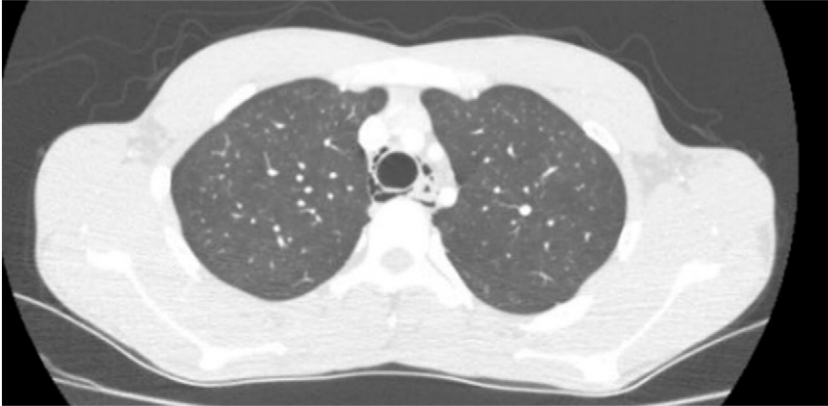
CT scan showing pneumomediastinum.
